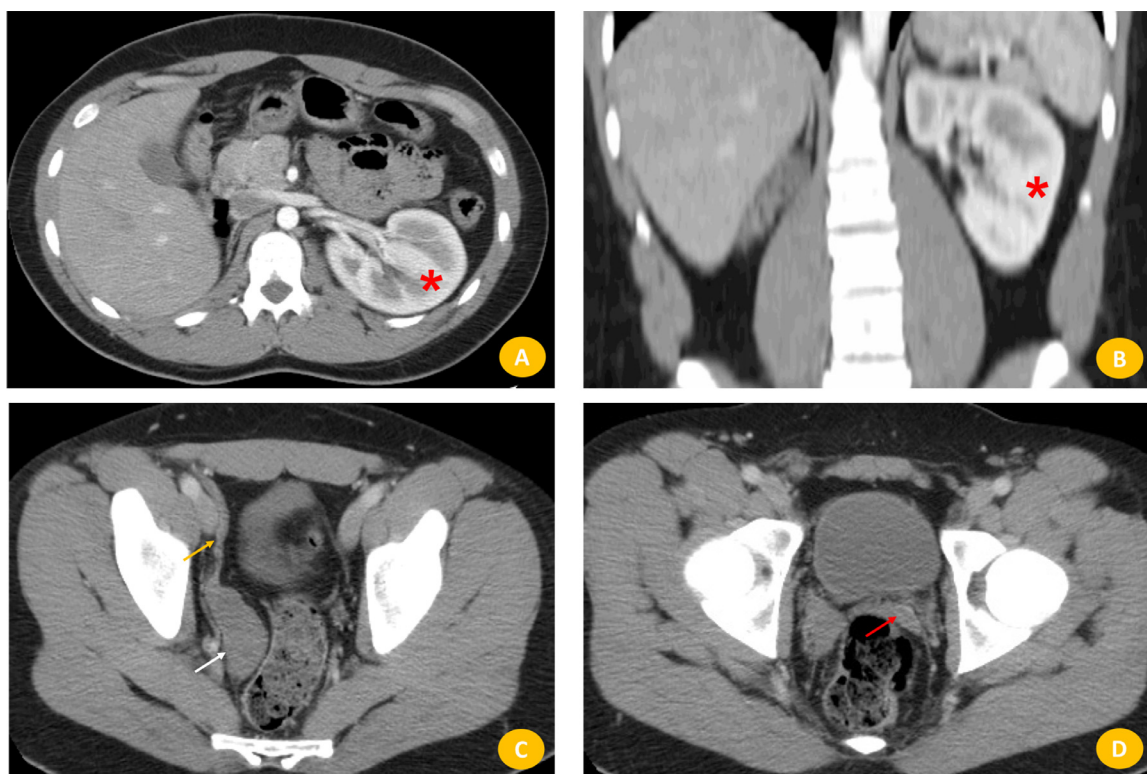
Abdominopelvic computerized tomography. (A and B) Axial and coronal CT-enhanced phase, reveal vicariant left kidney (*) and right kidney fossa empty. (C and D) Axial CT-enhanced phases reveal, seminal vesical asymmetric, right seminal vesicle is enlarged (white arrow) and efferent duct (orange arrow). Left seminal vesicle is normal morphology (red arrow). (Color version of figure is available online.)
